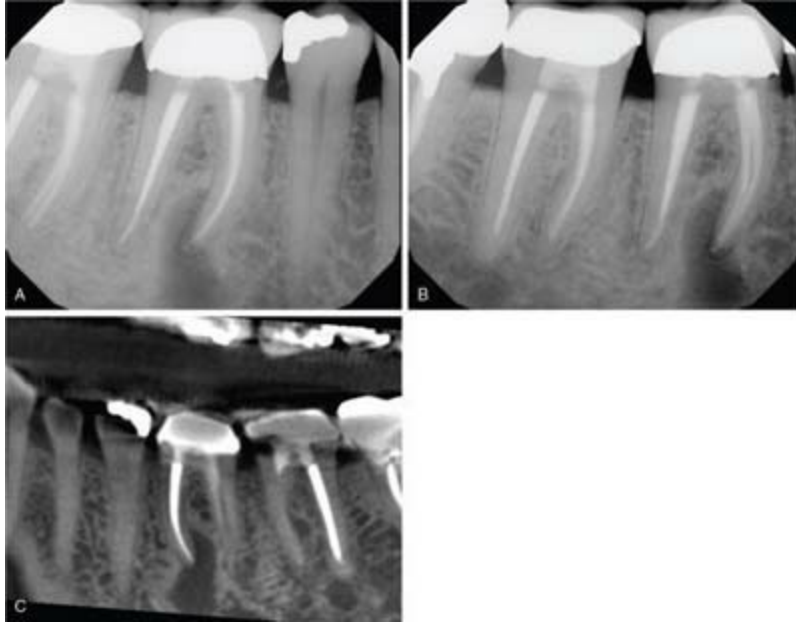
A, Periapical image of tooth #30 with a previous root canal and a well-defined radiolucency at the mesial root apex. B, Angled periapical image of the same tooth, further demonstrating the extent of the lesion. C, Sagittal CBCT demonstrating a loss of density at the mesial root apex of tooth #30. This well-defined lesion was sampled during an apical surgery, and the biopsy showed a periapical cyst.
